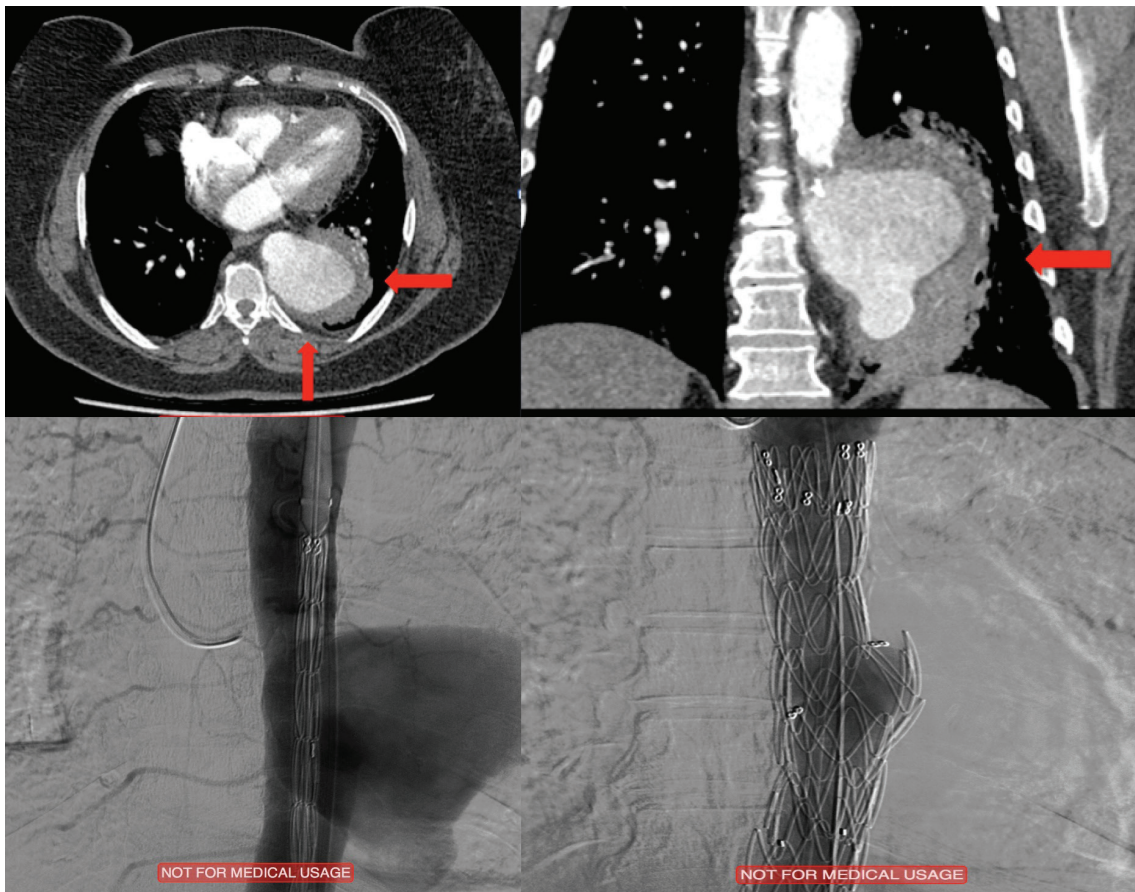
Computed tomography images of a thoracic aortic aneurysm rupture.
